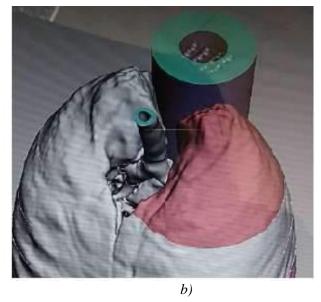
Visualization of the lungs according to spiral computed tomography: a) axial section, b) volumetric reconstruction
